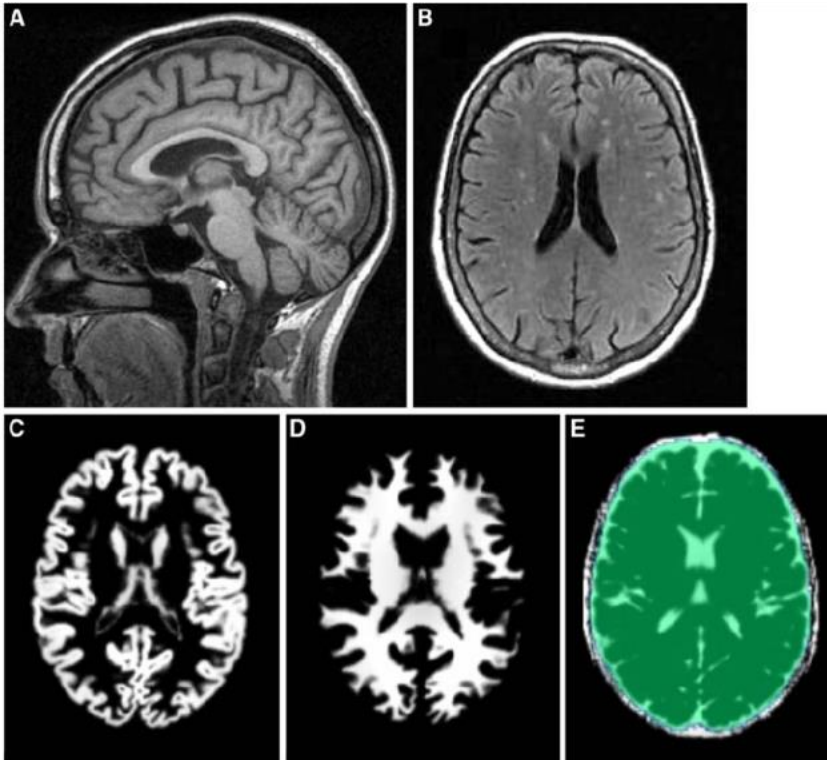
Example of MPRAGE image and segmentation into GM, WM and CSF. A.) High resolution T_1 -weighted image in the sagittal view. B) Demonstrates multifocal white matter lesions presenting as hyper intense areas on a FLAIR image. C-E show axial slices of GM, WM and CSF following segmentation and spatial normalisation.
